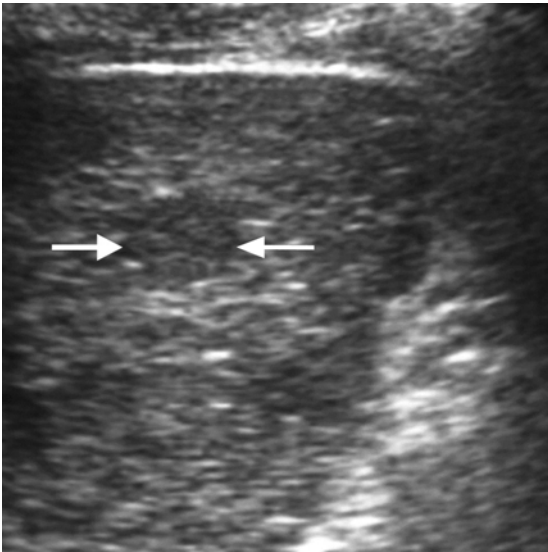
Ultrasound scan showing a small hypoechoic HCC (arrows).
